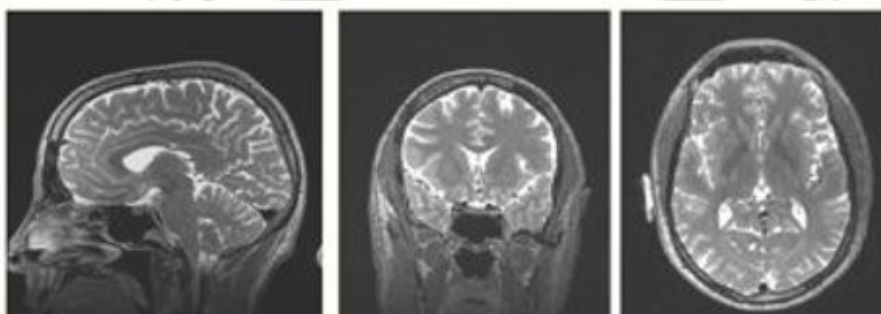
T2 weighted MRI image: Sagittal, Coronal, Axial View (Left to Right); Good contrast between CSF (bright) and brain tissue (dark). Some T2 sequences demonstrate additional contrast between grey matter (lighter grey) and white matter (darker grey). Fat, such as lipids in the white matter, appears dark [57]
